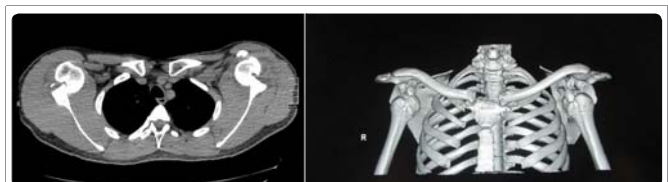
Same patient: computed tomography with reconstruction images: bilateral dislocation with bilateral notch of Malgaigne (or fracture of Hill Sachs).
